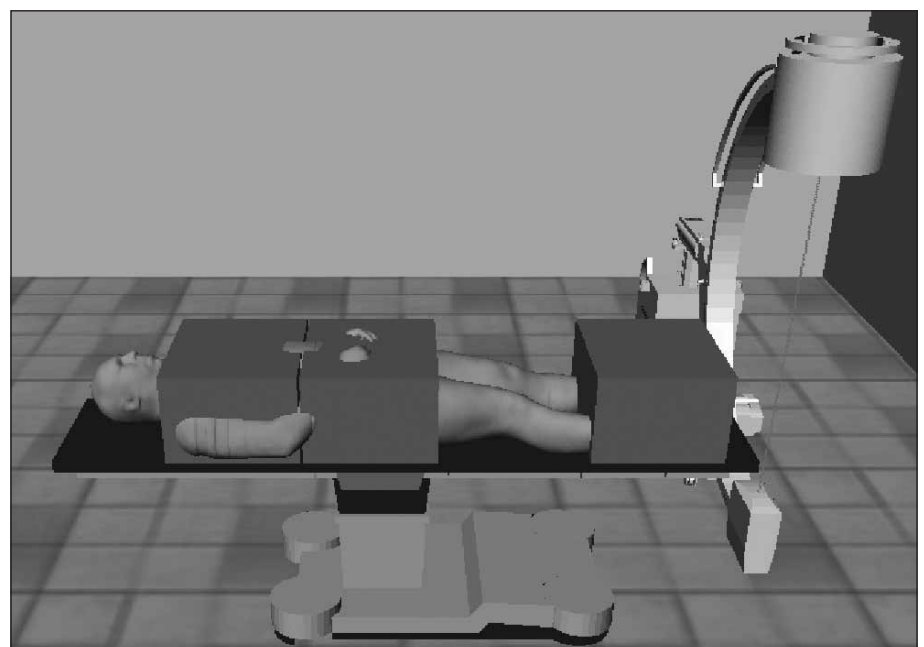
Registration of three CT data sets (depicted as boxes) with a 3D surface model of a virtual patient on the example of the Visible Human data set
